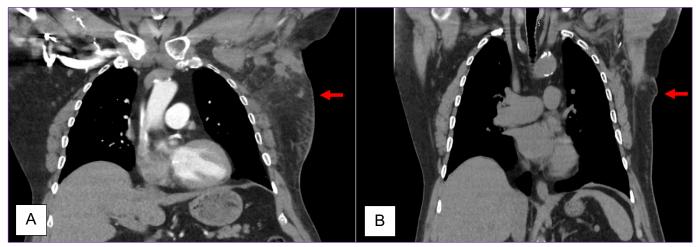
CT images (A) before and (B) after radiation and 4 cycles of cemiplimab.
